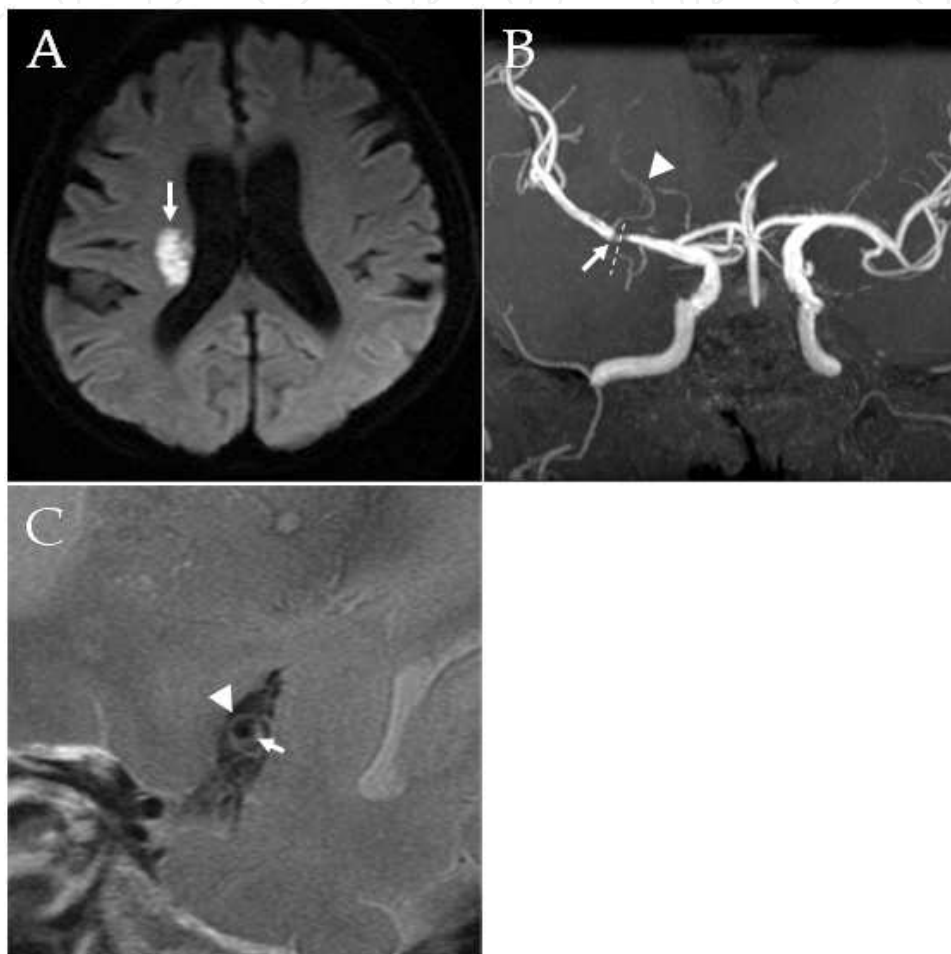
Middle cerebral artery plaque which is also detected by magnetic resonance angiography (modified from Niizuma et al., 2008). A: Axial diffusion-weighted image demonstrating a high-intensity lesion, 20 mm in diameter, in the right corona radiata (arrow). B: Magnetic resonance angiography processed by partial maximum intensity projection indicating the relationship between the stenotic area (arrow) and lateral striate arteries (arrowhead). C: High-resolution magnetic resonance image perpendicular to the right MCA, at the level of the dotted line on B (TR/TE 2800/50.8, FOV 12 cm \times 12 cm, matrix size 512 \times 256, slice thickness 2 mm, interslice gap 0.3 mm, NEX 5), presenting the lumen of the right middle cerebral artery (arrow) and plaque on the vessel wall (arrowhead).
